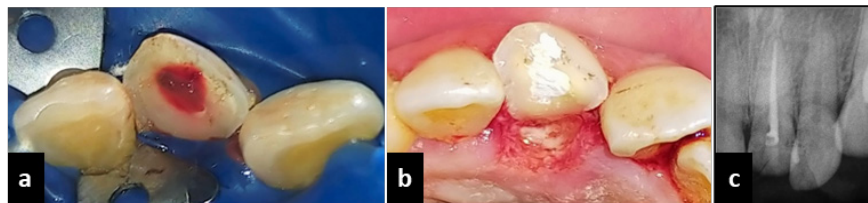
(a) Removal of the fractured fragment and isolation of the tooth with rubber dam, (b) coronal elongation: gingivectomy and osteoplasty, (c) postoperative radiograph. tooth with rubber dam, (b) coronal elongation: gingivectomy and osteoplasty, (c) postoperative radiograph. fracture line and the attached fragment, (b) preoperative intraoral radiograph.
